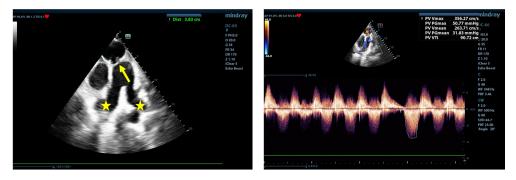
d.1. Pulmonary (re)stenosis 70 years after a pulmonary valvulotomy performed for tetralogy Fallot: markedly dilated pulmonary artery (3.83 cm) and of its principal branches (starred) (left, 2D, parasternal short axis) and increased pulmonary peak velocity  $V_{mx}$ =3.56 m/s with maximum gradient of 50 mmHg (right, color and CW Doppler)
